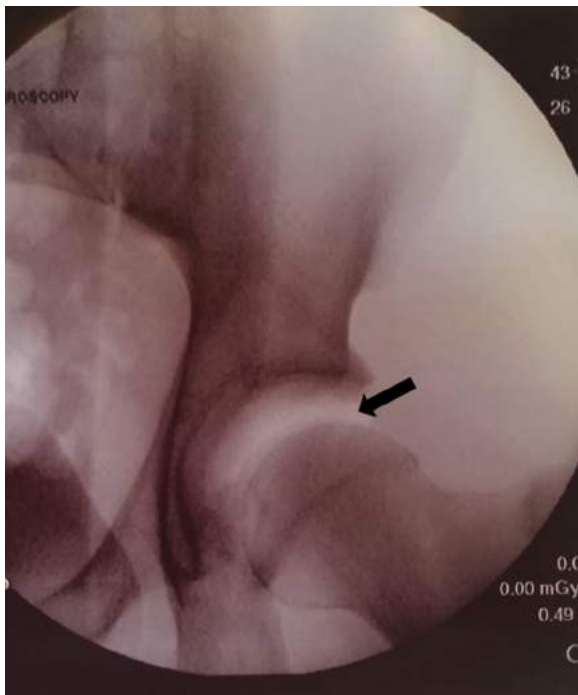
Intraoperative radiograph of a left hip verifying adequate joint distraction, as shown by the “vacuum” sign (arrow). A minimum of 10 mm of distraction is recommended for access to the central compartment to avoid chondral damage with instrument placement.
